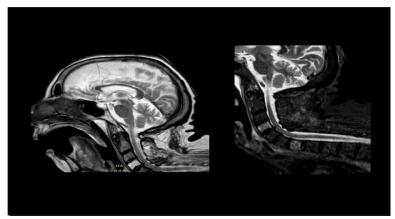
Brain and cervical MRI scan (respectively T2 and Stir sequences) showing mouth and tongue dystonia, associated with severe retrocollis. Spinal cord is forced in a 90 degrees bending due to contraction of paraspinal muscles.
